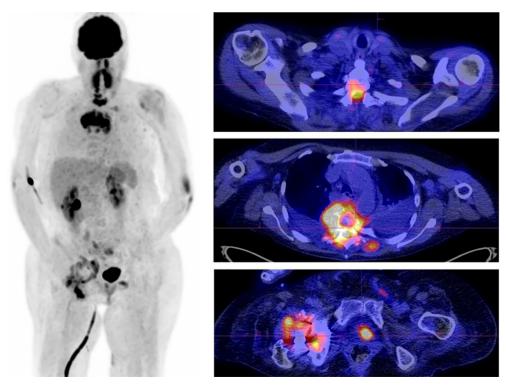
FDG-PET/CT (left MIP image, right transaxial fused PET/CT images) in a patients with a PJI, and spread of infection to the thoracic spine (spondylodiscitis).
